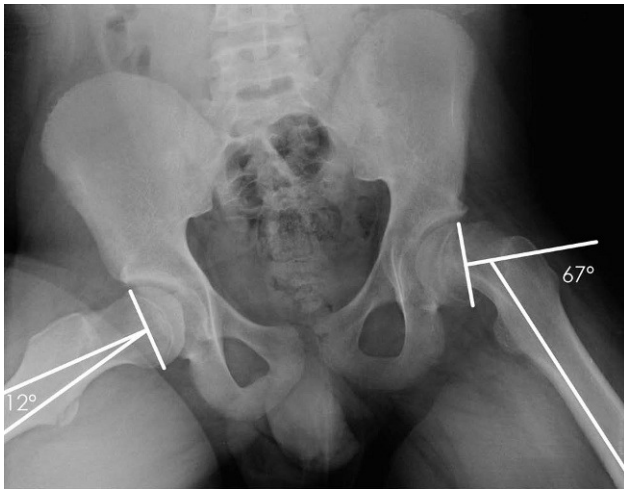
Lauenstein radiograph, showing the sequelae of severe SCFE on the left hip ($67-12^\circ = 55^\circ$).
